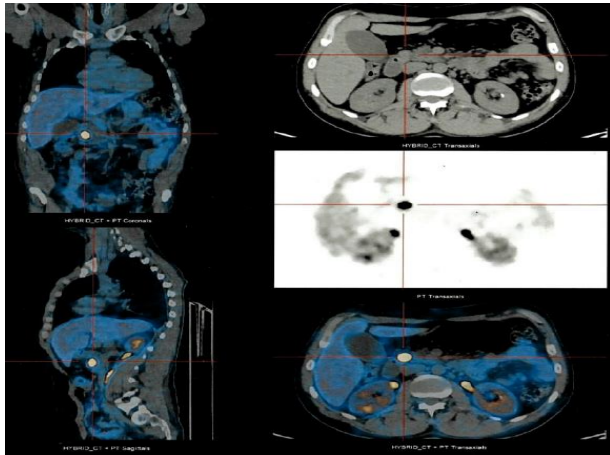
⁶⁸Ga-DOTA-NOC PET/CT showing a nodular structure in pancreatic head overexpressing somatostatin receptors.
